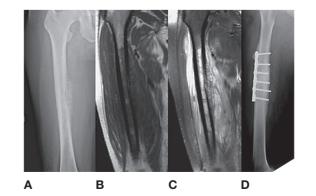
Osteomyelitis of the femur. (A) Plain film of the femur showing periosteal reaction. (B) T1-weighted MRI. (C) T2-weighted MRI. (D) Plain film 18 months post–open-reduction and internal-fixation surgery. (Reproduced with permission from Huang P-Y, et al. Osteomyelitis of the femur mimicking bone tumors: A review of 10 cases. *World J Surg Oncol.* 2013;11:283.)
